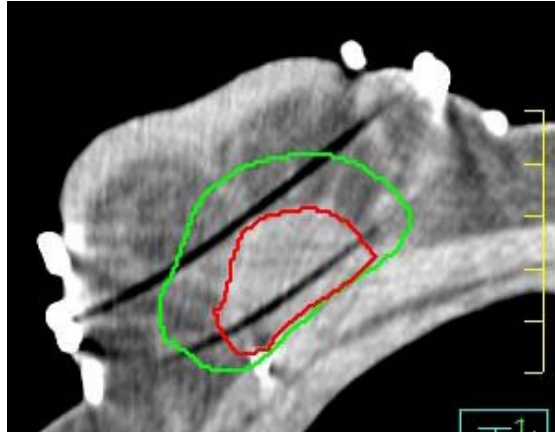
Post-implant CT-image based definition of the PTV. Excision cavity (red); PTV (green)
